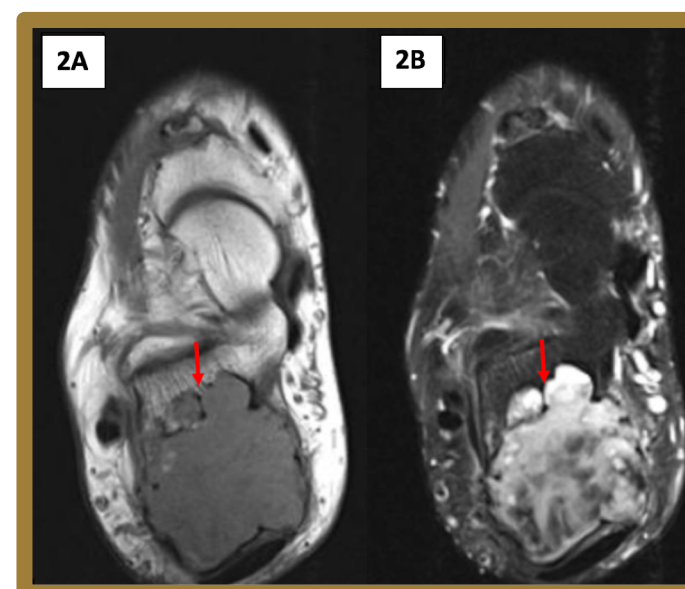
MRI coronal images (A) T1 sequence-intermediate signal and (B) T2 sequence-predominant heterogeneous hyperintensity.
